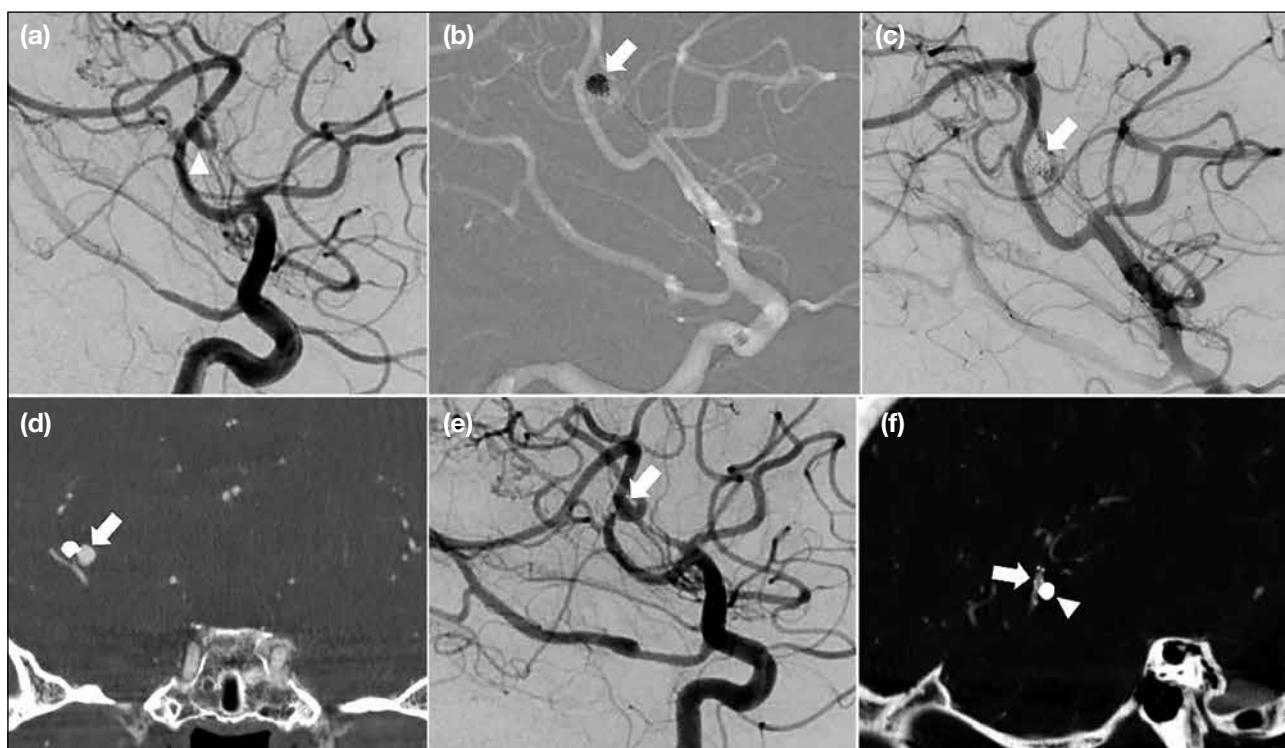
Same patient as Figures 3 and 4. Follow-up computed tomography angiography (CTA) 2 months later showed a persistent M2 mycotic aneurysm (not shown). (a) Oblique projection of digital subtraction angiography (DSA) of the right internal carotid artery (ICA) shows a lobulated M2 mycotic aneurysm arising from the middle cerebral artery (arrowhead). (b) DSA with the roadmap technique enabled neuronavigation for precise embolisation of the mycotic aneurysm (arrow). (c) Post-embolisation DSA of the right ICA shows the successfully embolised right M2 aneurysm (arrow), with preservation of distal flow. (d) Follow-up coronal cone beam CTA 2 months post-embolisation shows a new saccular aneurysm adjacent to the previously embolised aneurysm (arrow). (e) Oblique projection DSA of the right ICA confirms the presence of the new narrow-neck mycotic aneurysm arising from the medial wall of the M2 segment (arrow). (f) Coil embolisation of the second aneurysm was performed, and a flow diverter was deployed across the aneurysmal neck. Follow-up sagittal cone beam CTA 1.5 years later shows the flow diverter in situ (arrow), with successfully embolised aneurysm (arrowhead). The stent remains patent and the distal branches are preserved.
